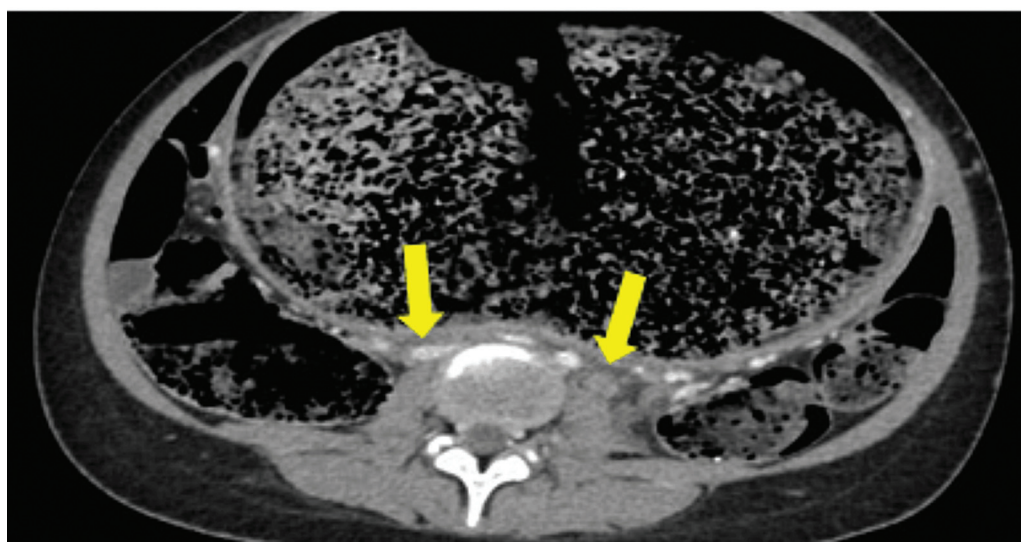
Contrast-enhanced computed tomography abdomen (CECT-ABD) (venous phase) axial section showing thrombosed left common iliac vein.
